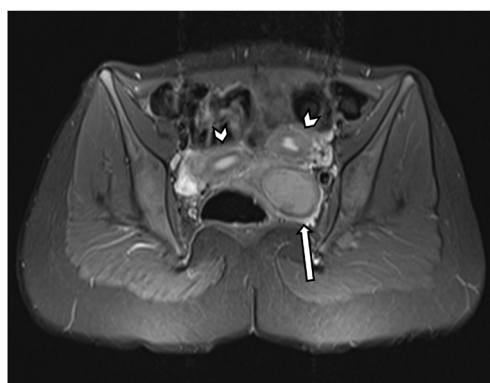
Upper pelvic axial T2 fat sat MRI, normal left and right uteri "arrow head", dilated left vagina "long arrow".
